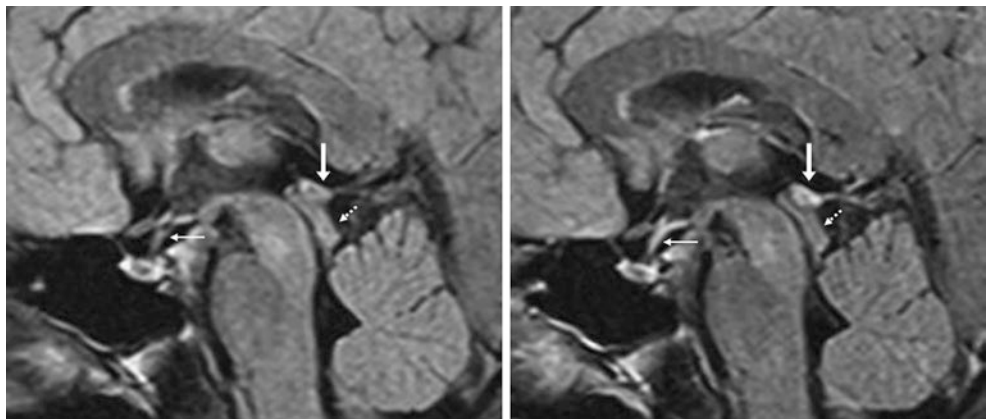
A 57-year-old patient with an incidental upper limit of a normal sized pineal gland (arrows), measuring 9 mm on three dimensional sagittal (left) and axial (left middle) FLAIR, without reduced diffusion
